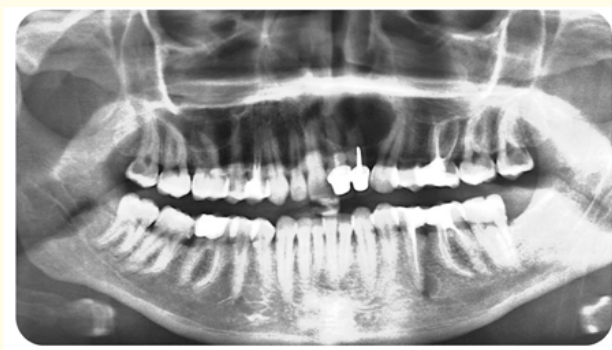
Preoperative panoramic radiograph showing a cystic lesion next to the 22 and extending to the 21.
